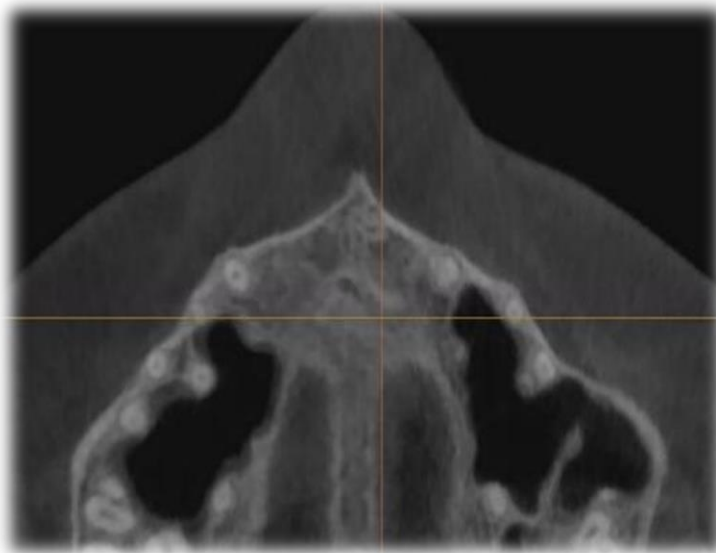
CBCT images of the periapical lesion healing process three years after the root canal retreatment.
